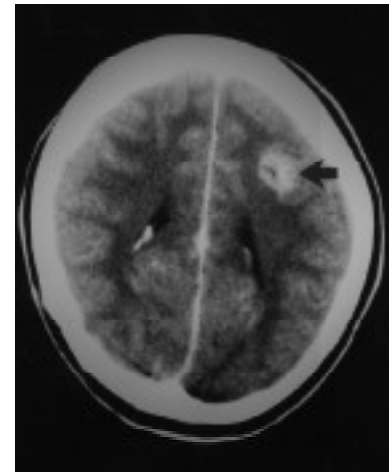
Enhanced CT scan in the same patient as Fig. 4a shows enhancement of the lesion with a small low density focus of gliosis within the lesion.
